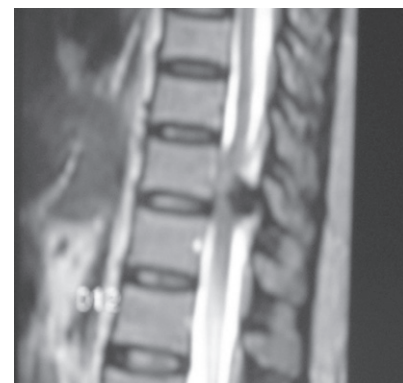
T2-weighted MRI shows uniformly hypo dense lesion situated posterior to the thecal sac in the lower thoracic region at level of tenth dorsal vertebra causing cord compression.
